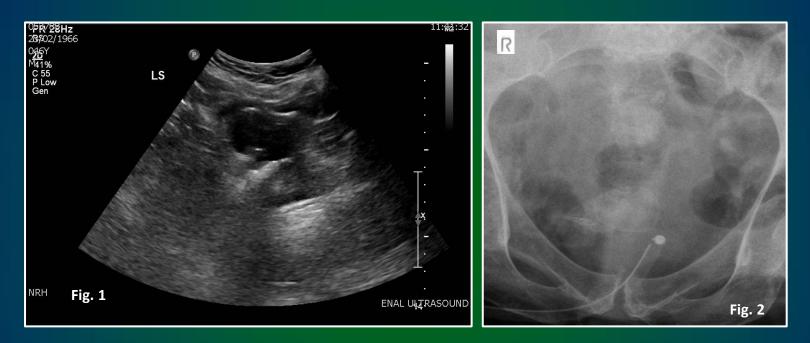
US showing decompressed bladder around IDUC. X-ray in same patient confirming large calculus not visualised on US.
